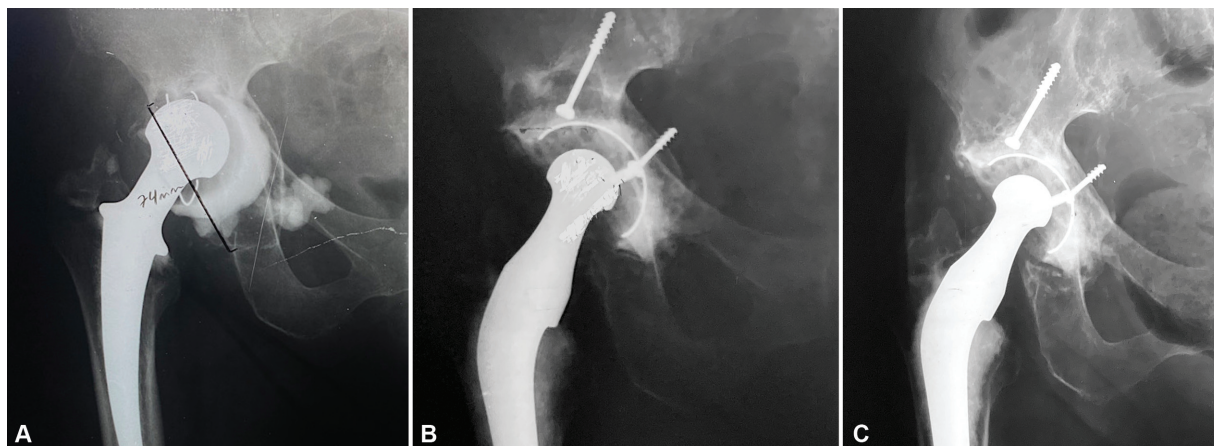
Radiographs of a 74-year-old female patient who had her right hip operated. A) preoperative radiography showing cemented total hip arthroplasty with combined defect (D'Antonio); Paprosky 3A, measuring 74 mm; B) immediate postoperative radiography presenting acetabular reconstruction with structural graft and cemented acetabular component; C) postoperative radiography at 18 years and 9 months after acetabular reconstruction without signs of loosening.
